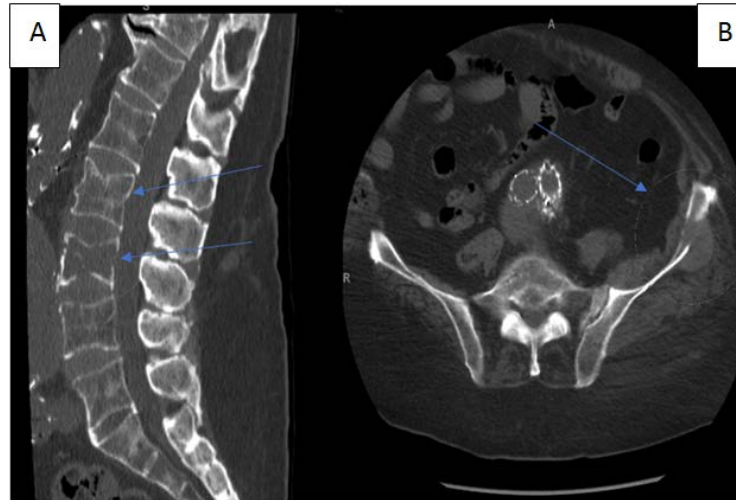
CT scan of the lumbar spine (A) and hip (B) showing pathologic fracture involving the L3 vertebral body, smaller pathologic fracture involving the L2 superior endplate, and multiple lytic destructive bone lesions with adjacent soft tissue lesions involving the left hip and femur without evidence of pathologic fractures
